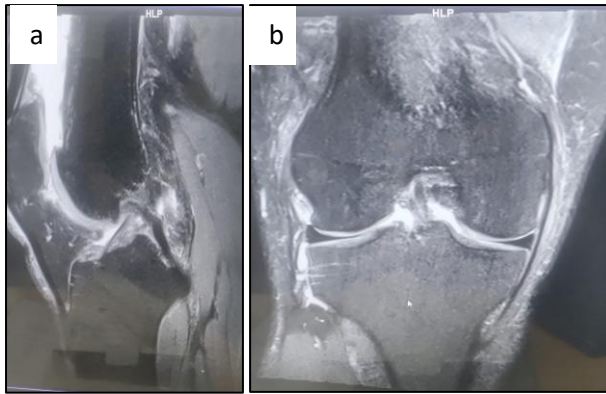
MRI image (a) sagittal and (b) coronal views.
